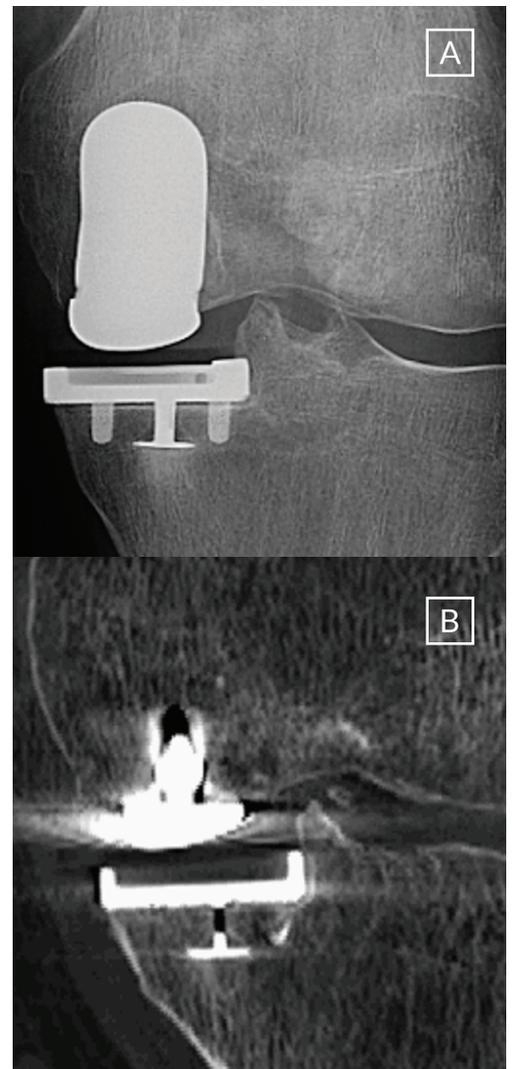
(A) Aligned A/P radiograph of a 60 year-old male patient with a left medial PKA at approximately 5 months post-op demonstrating a physiologic RLL. (B) Coronal CT image of same male patient demonstrating a well-integrated tibial tray on CT. Both X-ray and CT were taken on the same office visit.
